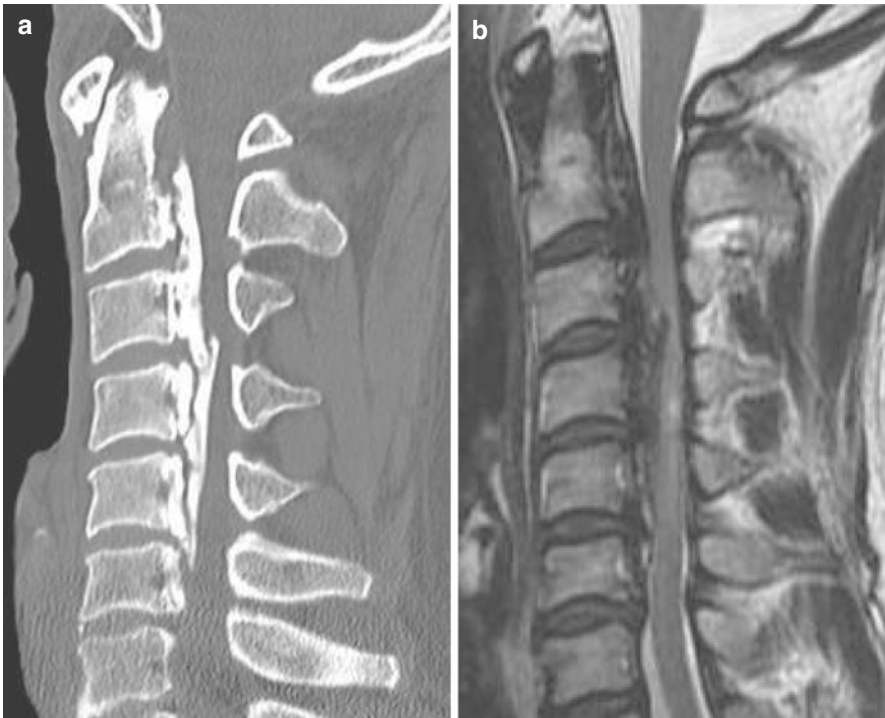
CT (a) reveals OPLL. OPLL is one of the causes of spinal cord compression by MRI (b)
